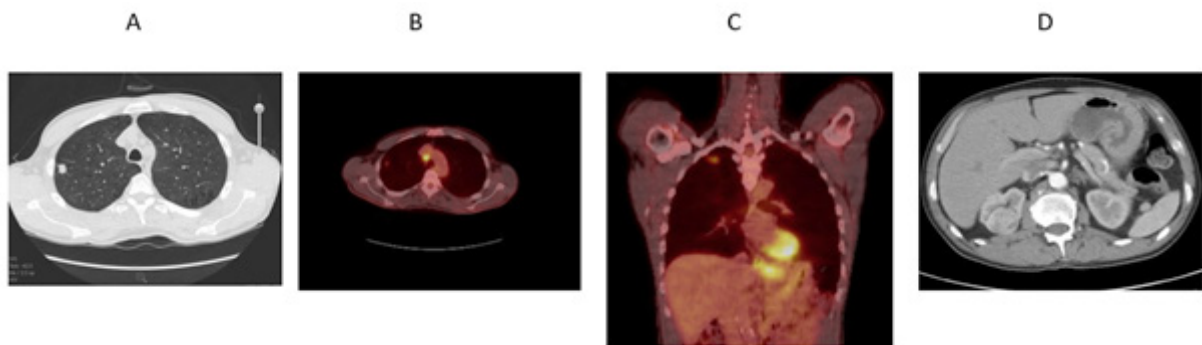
(A) CT showing a right upper lobe pulmonary nodule (B) CT PET showing an avid nodule and a station 4R lymph node (C) CT PET showing an increased uptake at gastroesophageal junction (D) CT showing mass in the right kidney.
